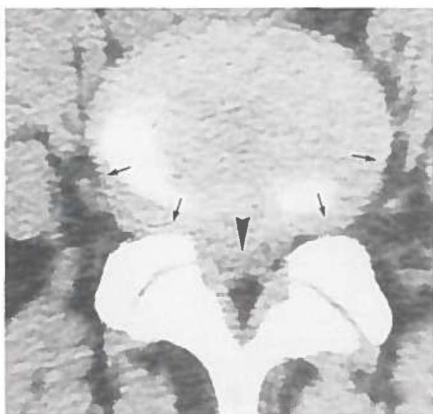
Case 3. CT scan at the same level three months after chemonucleolysis, showing asymmetrical protrusion of the disc (arrowhead) apparent on the right, the obvious increased diffuse bulging of the annulus with obliteration of foraminal fat at this level (small arrows).
